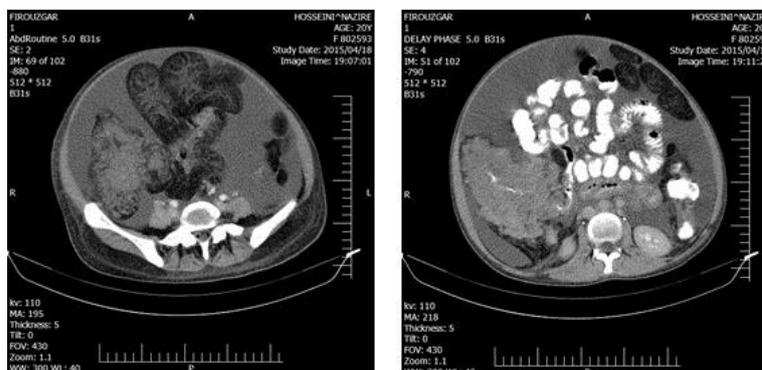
A giant colon microcystic mass (180×102 mm) on psoas muscle using spiral CT scan
